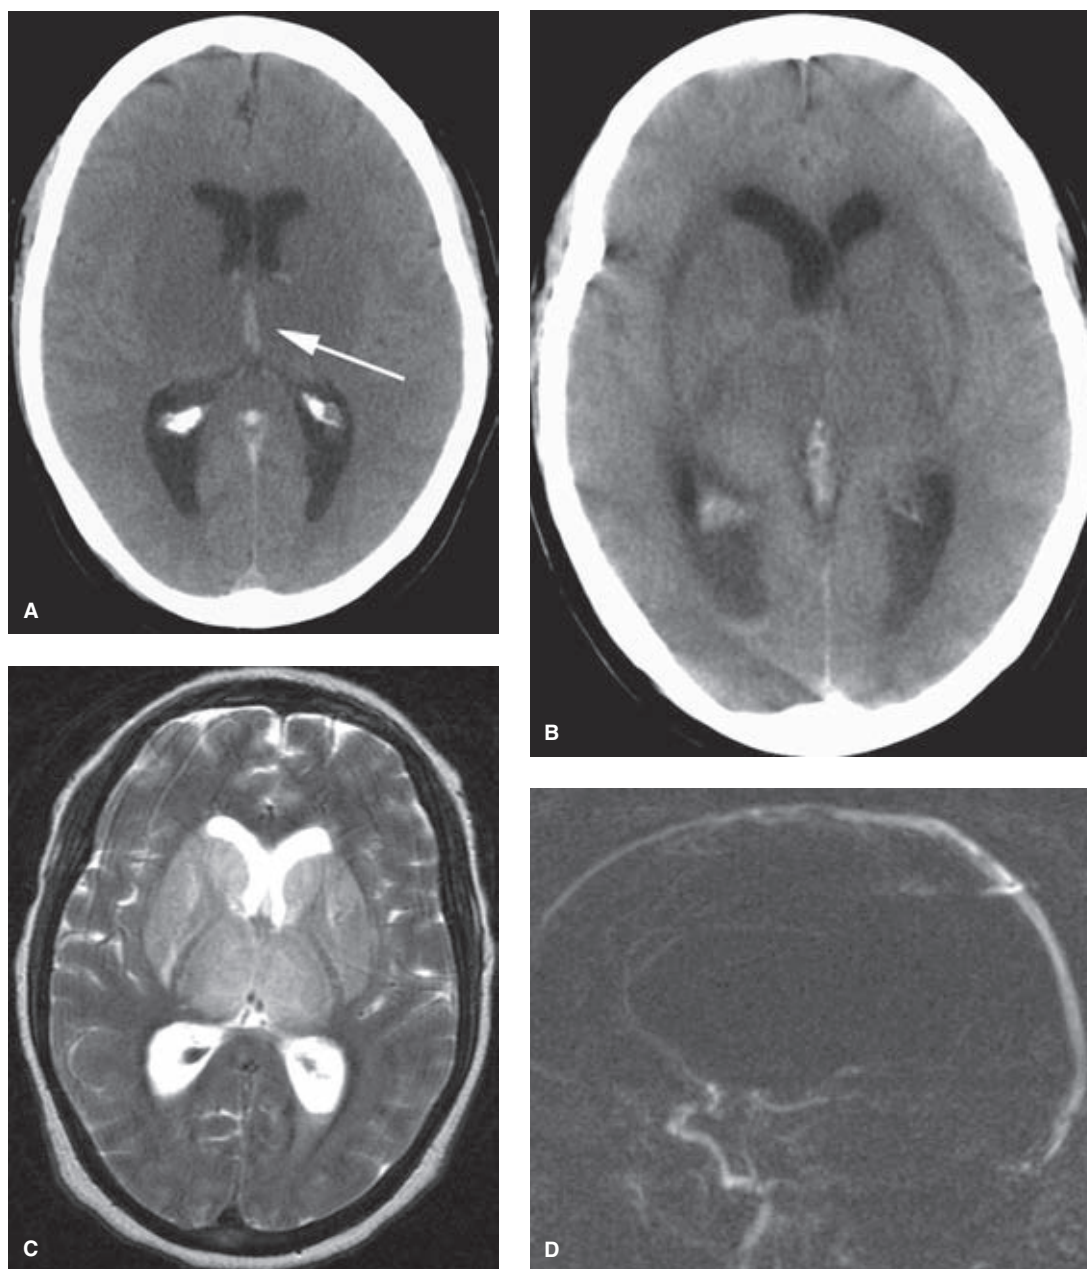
(A–G) Extensive DVT with profound neurologic decline. An elderly female patient living alone was found unconscious by her neighbors following a 2- to 3-day period during which she had been taking antibiotics for a minor urinary infection. Her first CT scan (A) and follow-up scan the next day (B) show extensive brain edema, intraventricular hemorrhage, hydrocephalus, and dense thrombus in the internal cerebral veins (*arrow* in A). The T2-weighted MRI (C) shows layering blood in the ventricles and diffuse hyperintense signal in the basal ganglia and thalami, an appearance that could be mistaken for a variety of toxic or infective encephalitides. The phase-contrast MRV (D) and left common carotid arteriogram (E) show no evidence of filling of the internal cerebral vein, minimal filling of the straight sinus with a linear filling defect (*arrow* in E), and drainage only via the left transverse sinus. (*continued*)
